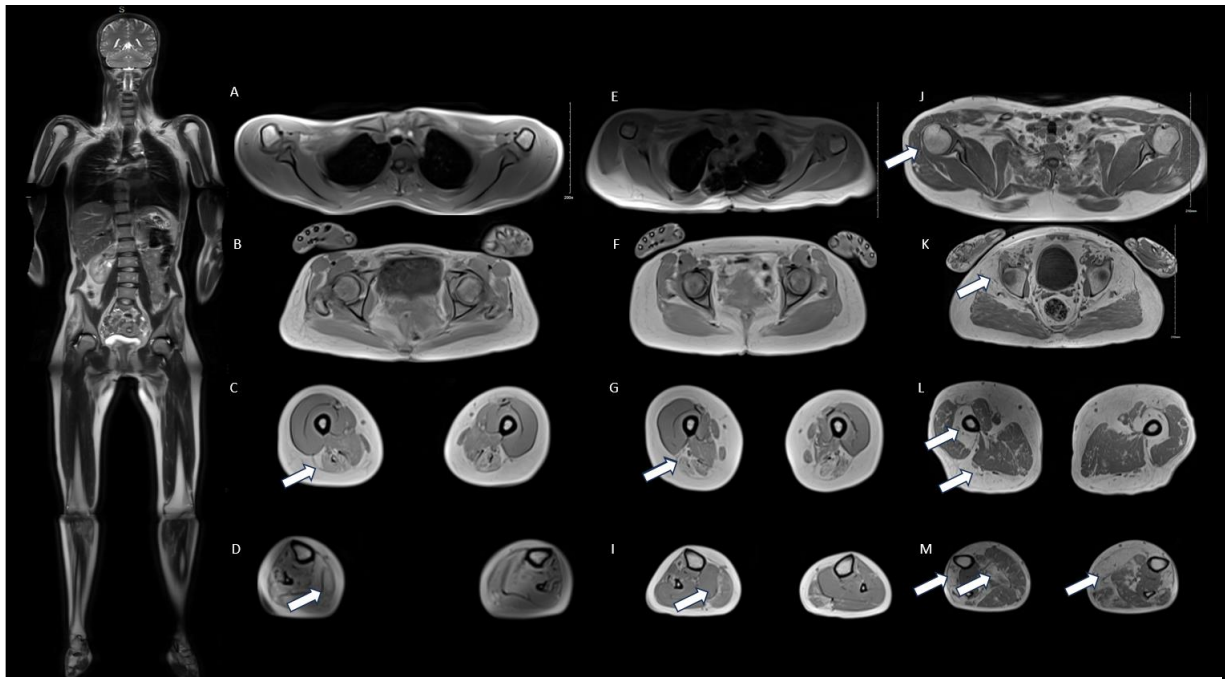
MRI Findings in cohort of patients with *TTN* myopathy
